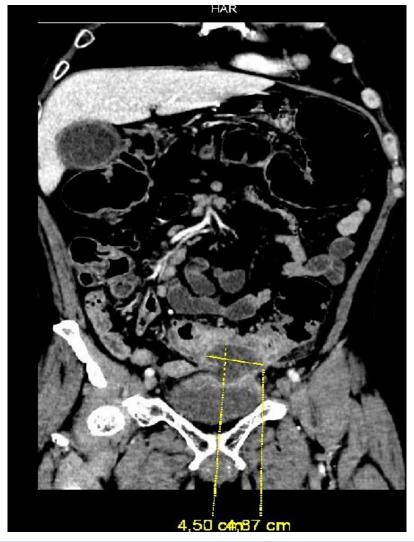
Coronal section of abdominopelvic CT, with abscess measuring 4.5 x 4.87 cm
